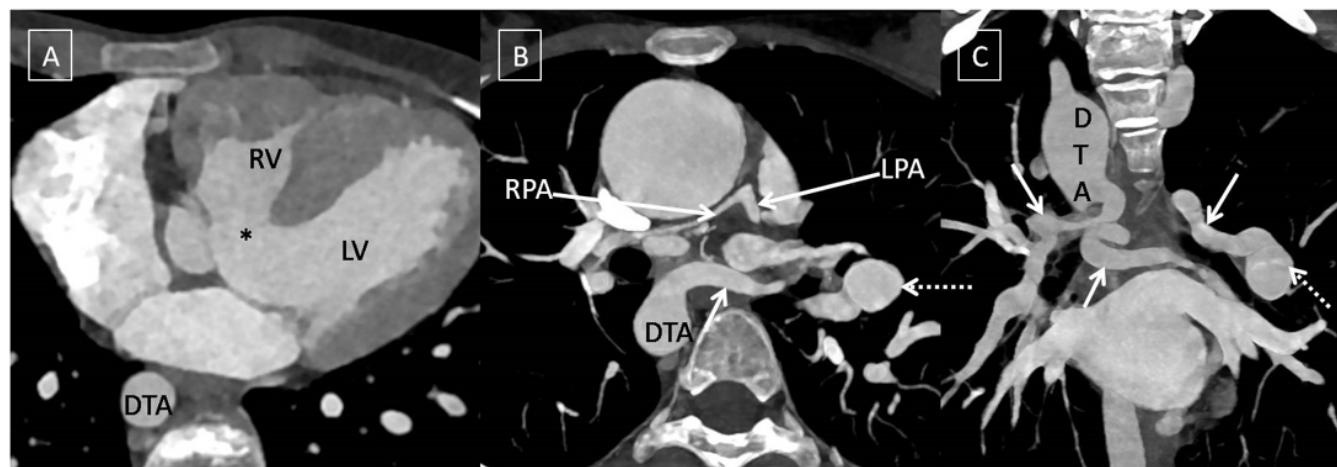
CT angiography images (A-C) showing large subaortic ventricular septal defect (*) with pulmonary atresia and confluent small pulmonary arteries. Major aortopulmonary collateral arteries (solid arrows) were seen arising from descending thoracic aorta (DTA) and the left subclavian artery with stenosis along their course and one of the collateral artery showing aneurysm (dashed arrow).
